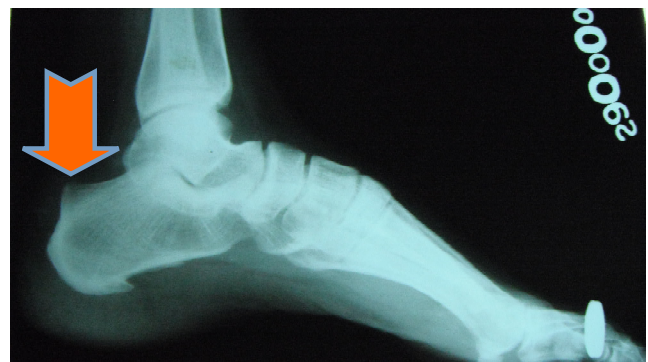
Pre-op x-ray showing bony overgrowth
